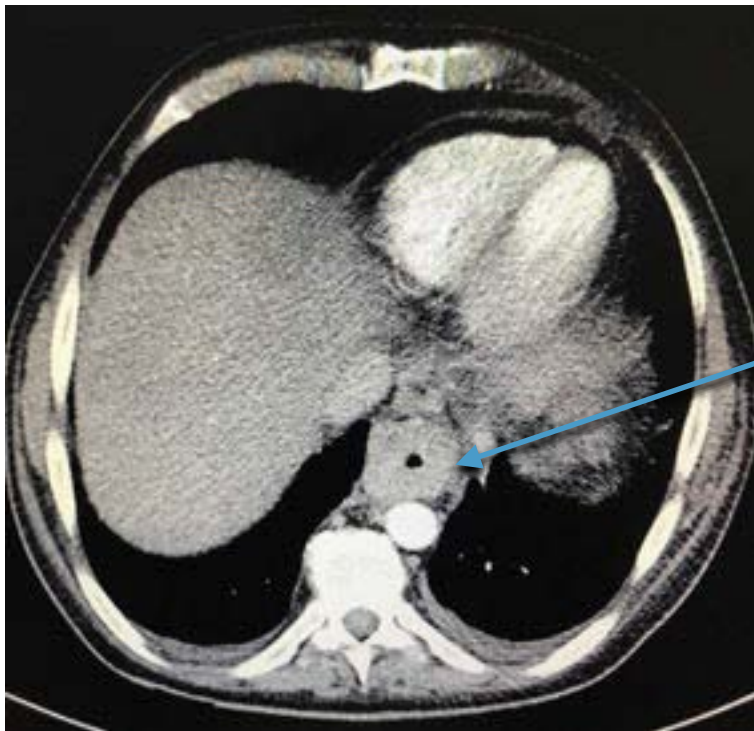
CT Scan sagittal views of the chest and abdomen shows thick walls of the distal oesophagus due to oesophageal tumour.
